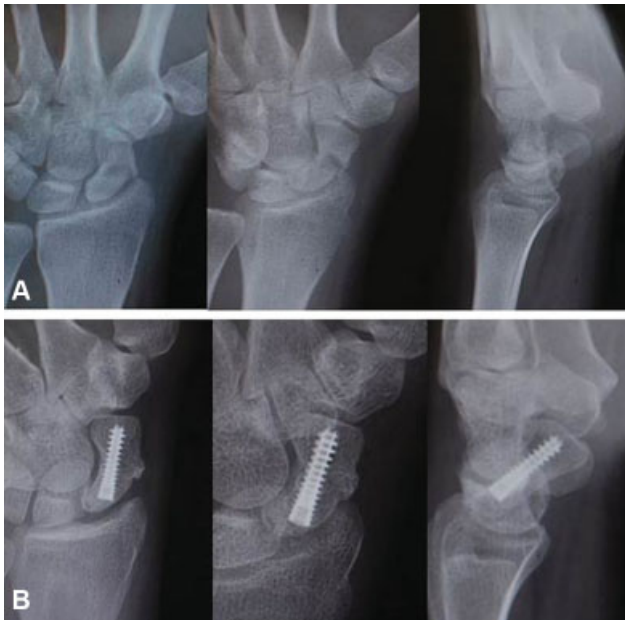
(A) Preoperative radiographs of an 18-year-old woman with a displaced 9-week-old left scaphoid waist fracture sustained in an all-terrain vehicle accident that was initially treated nonoperatively. Computed-tomography scan showed mild displacement in addition to some cystic formation within the waist region consistent with a grade IV nonunion. She subsequently underwent open reduction and internal fixation with cancellous distal radius autograft using the “drill and fill” technique. (B) Two-month postoperative radiographs of the same patient show a healed scaphoid nonunion.
